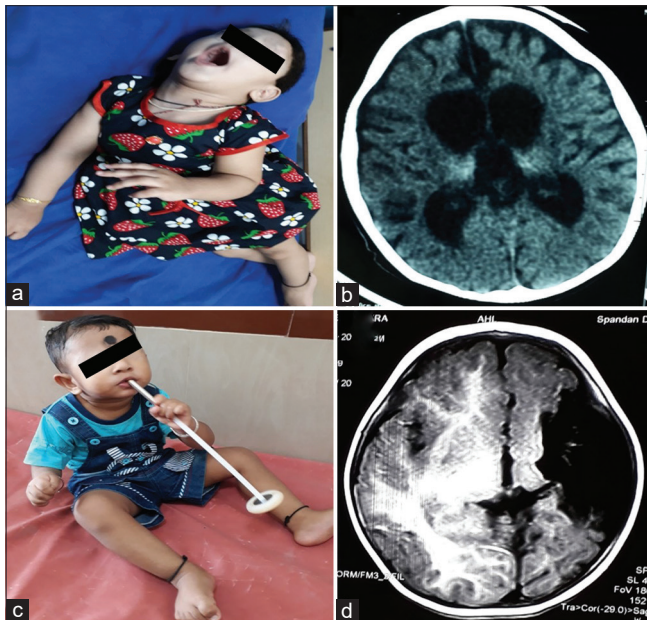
(a and b) Child with dyskinetic cerebral palsy with magnetic resonance imaging (MRI) (b) brain T2 axial showing hyperintensities in bilateral posterior putamen and thalami suggestive of acute hypoxic insult. (c and d): Child with dyskinetic cerebral palsy with dystonic posturing and arching of neck due to dystonia and MRI brain (d) T2 axial showing bilateral symmetrical hyperintensities in globus pallidus due to bilirubin-induced neurologic dysfunction.
